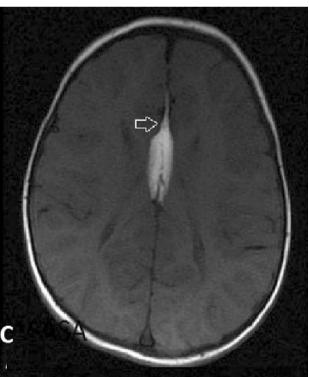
(A-D): Contagious axial T1W MRI (A) with fat saturation (B) showing fat fluid level, with ICA encasement on T2W images (arrow in D)
